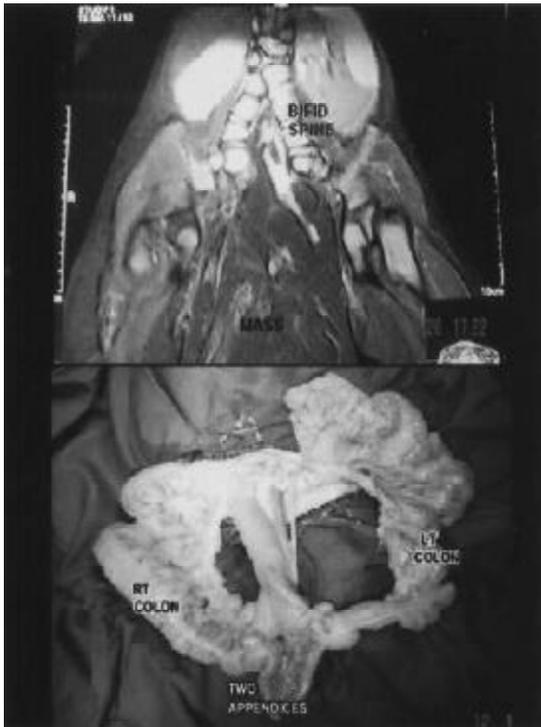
MRI revealed a bifid spine below L1, a bifid sacrum, duplicated colon, single right kidney, absent mullerian structures and a solid mass with incompletely formed feet and cartilaginous structures.
